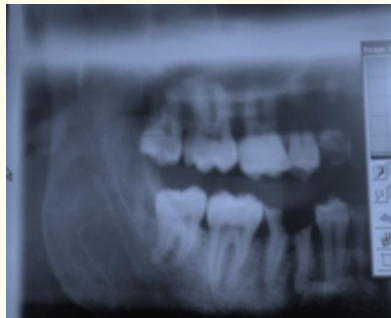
OPG x-ray showing estimated level of nerve.
